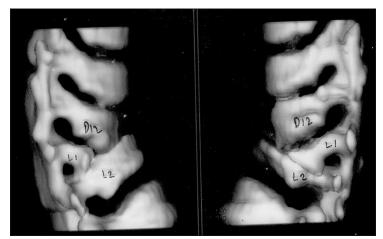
CT scan of dorsolumbar spine (3D) showing tuberculous lesion similar to congenital kyphosis type I (Patient: F/4.5 years, with three years after healing of tuberculosis lesion)
